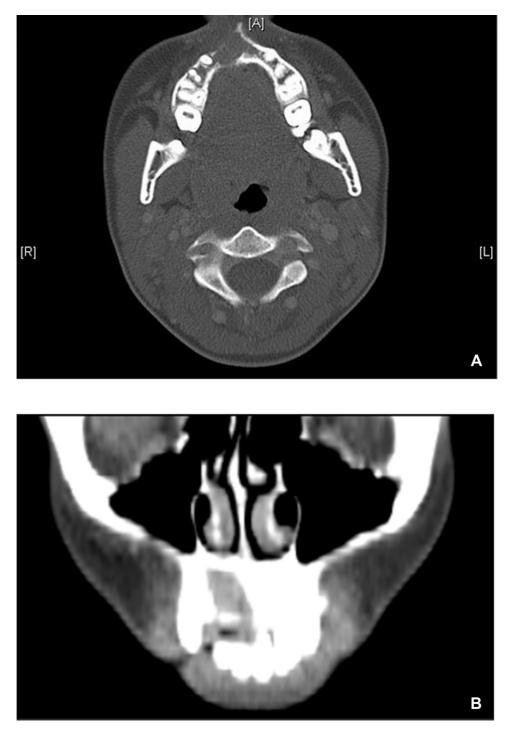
Preoperative computed tomography (CT) scan without contrast, demonstrating an ill-defined radiolucency involving the right anterior maxilla (A) and its superior extent abutting the nasal floor (B).
